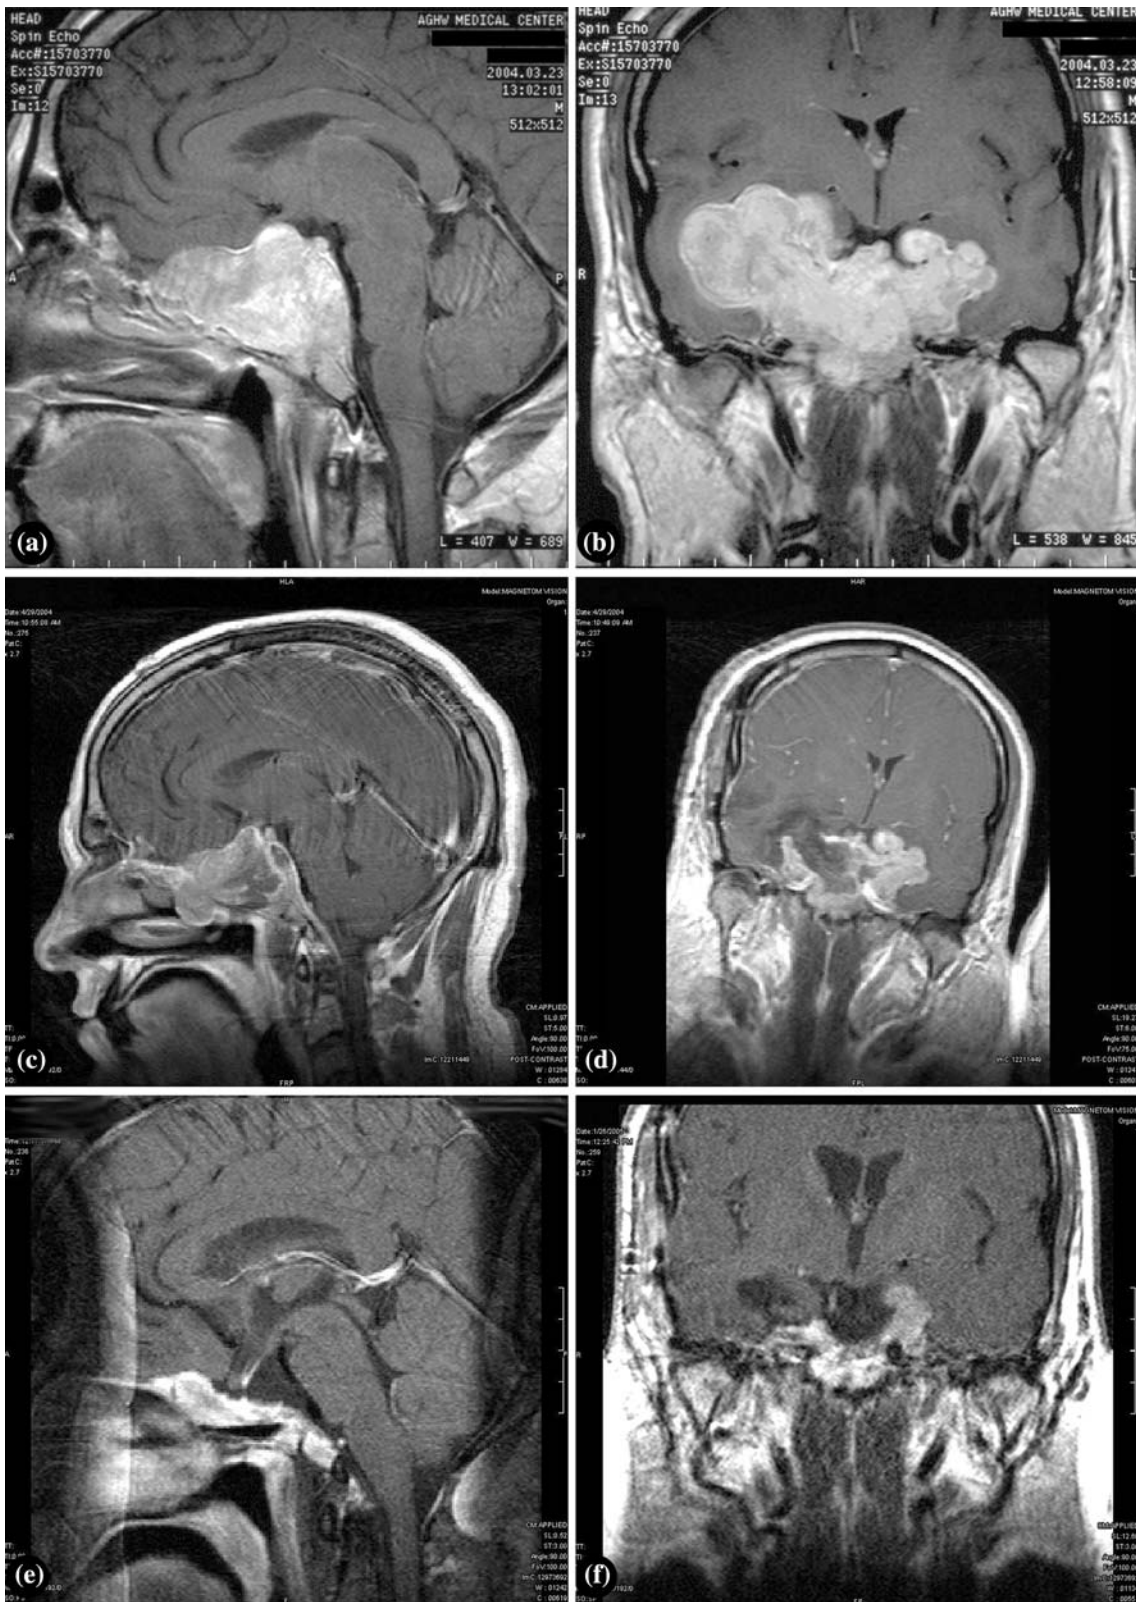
Sagittal and Coronal T1 weighted MR image of giant skull base tumor with suprasellar extension prior to surgery (a, b), postop (c, d) and 9 months after therapy with Cabergoline (e, f).
